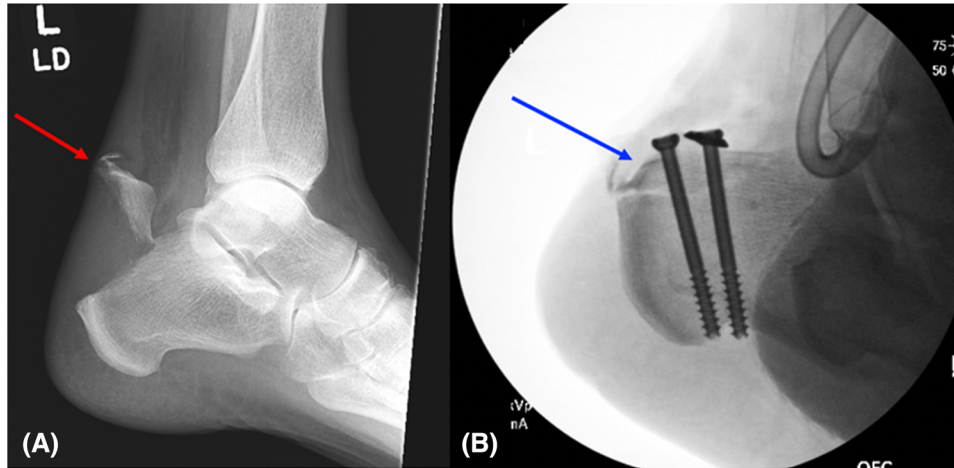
(A) Left ankle radiograph was remarkable for an acute fracture of the posterior proximal aspect of the left calcaneus (red arrow) with involvement of the Achilles tendon insertion site. (B) Intraoperative radiograph status-post 2 cannulated screws (blue arrow) driven into the left calcaneus.
